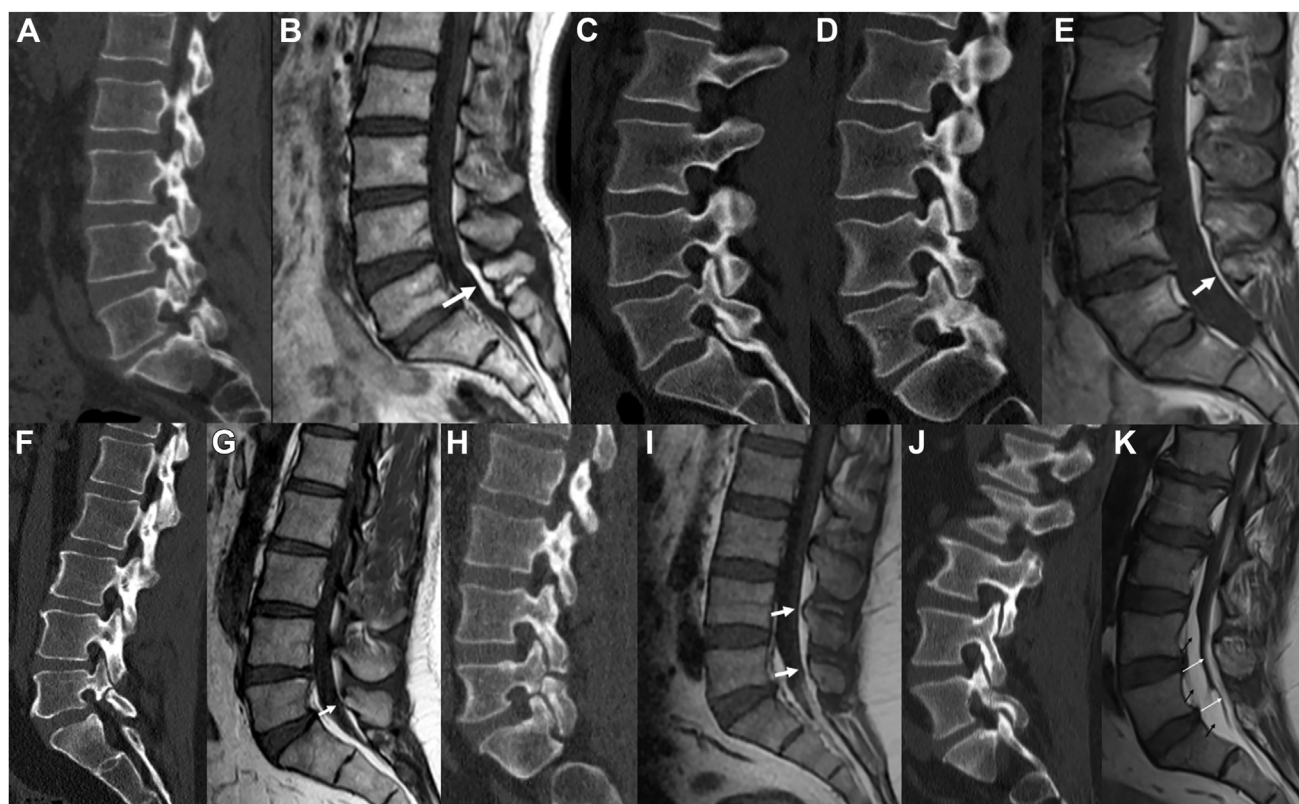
(A) The 10th patient with bilateral spondylolysis (SL) had a pars defect on lumbar CT and (B) EFI positivity on lumbar T1-W MRI (arrow). (C) The 20th patient with unilateral SL had intact pars on CT, (D) a pars defect on the left, and (E) EFI positivity on lumbar T1-W MRI (arrow). (F) The 30th patient with bilateral SL had a pars defect on lumbar CT and (G) EFI negativity on lumbar T1-W MRI. (H) The 40th patient with bilateral SL had a
